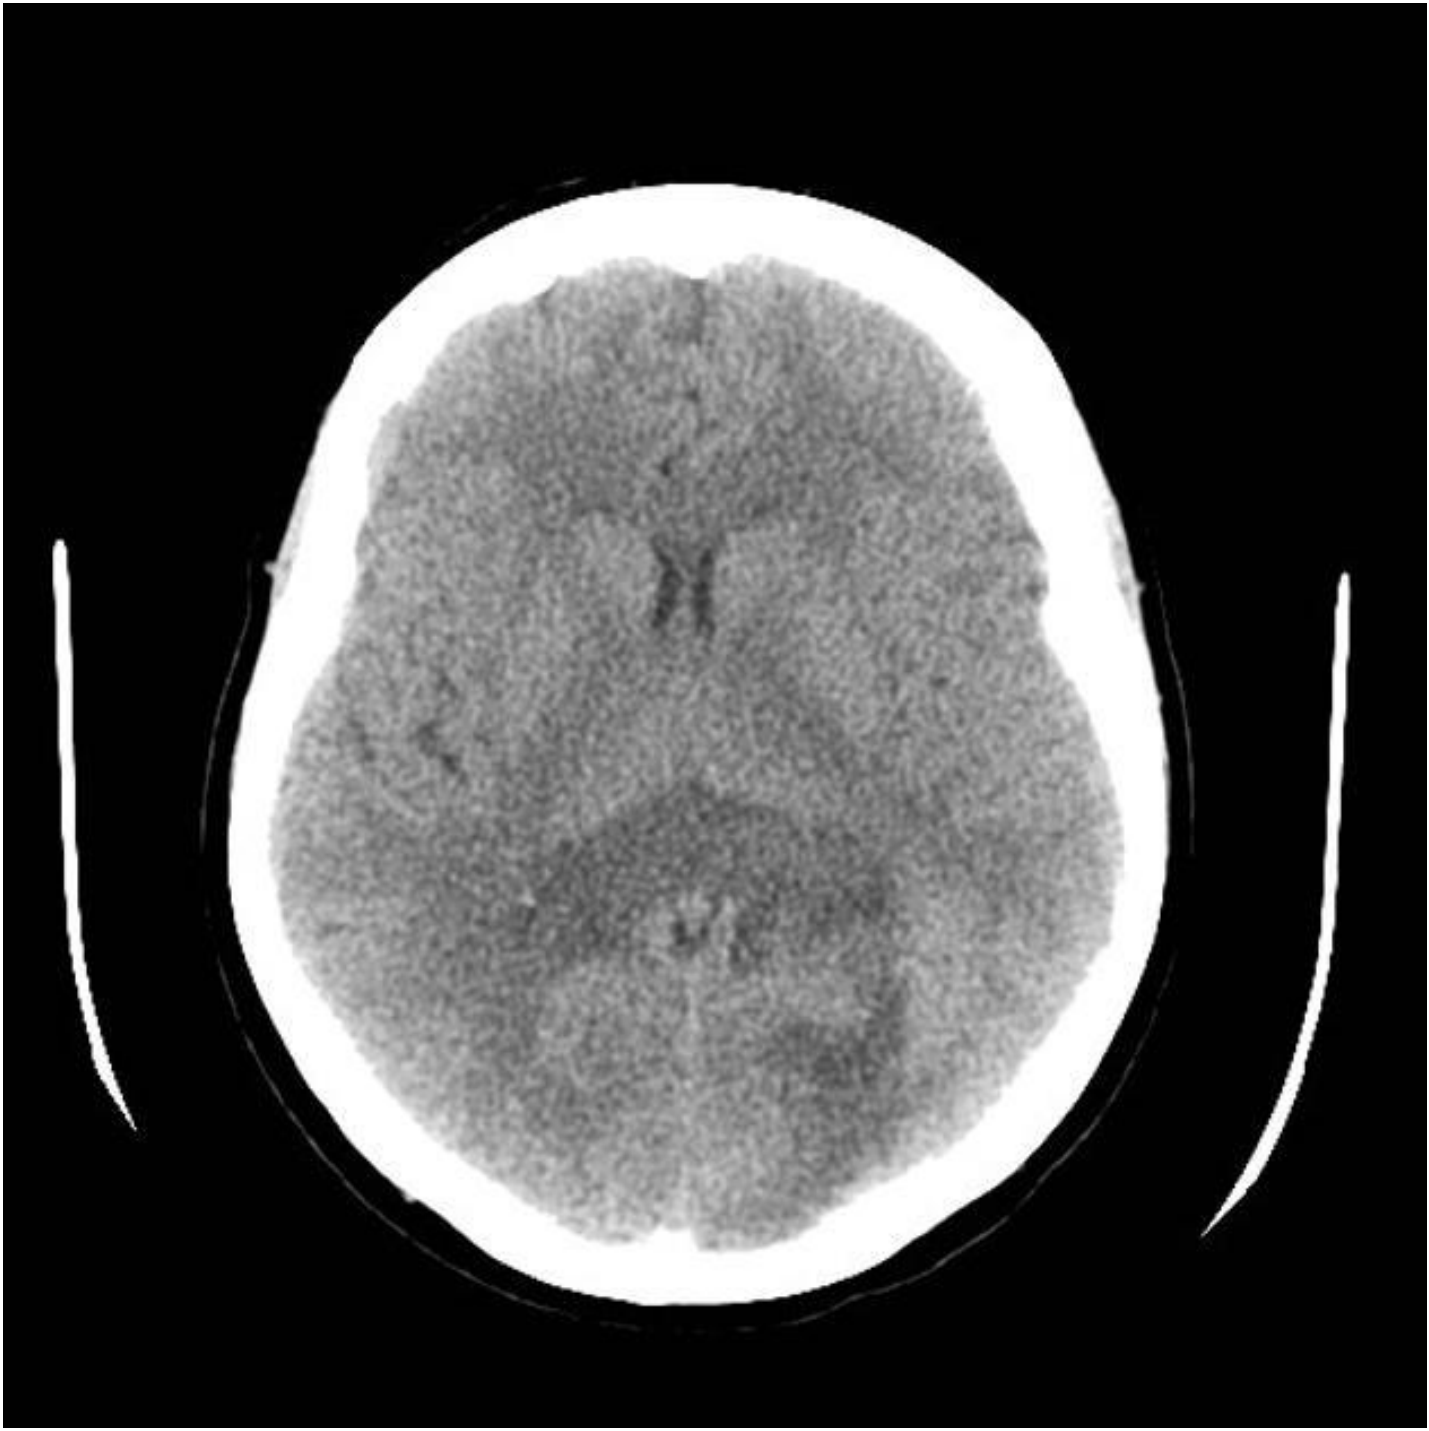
CT scan, axial view, showing a heterogeneous mass extending across the posterior corpus callosum
